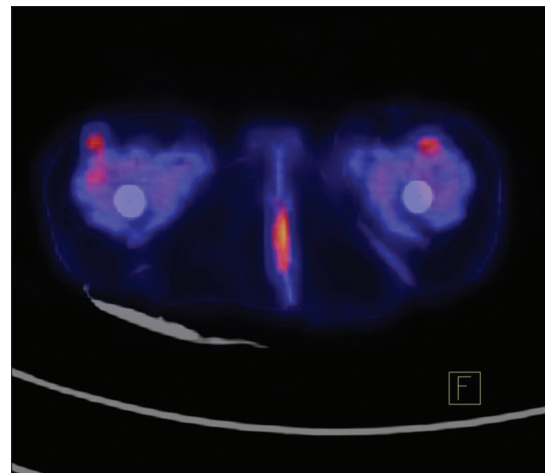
Select fused computed tomography and attenuation corrected axial 18F-fluorodeoxyglucose (18-F-FDG) positron emission tomography images of the bilateral thighs
